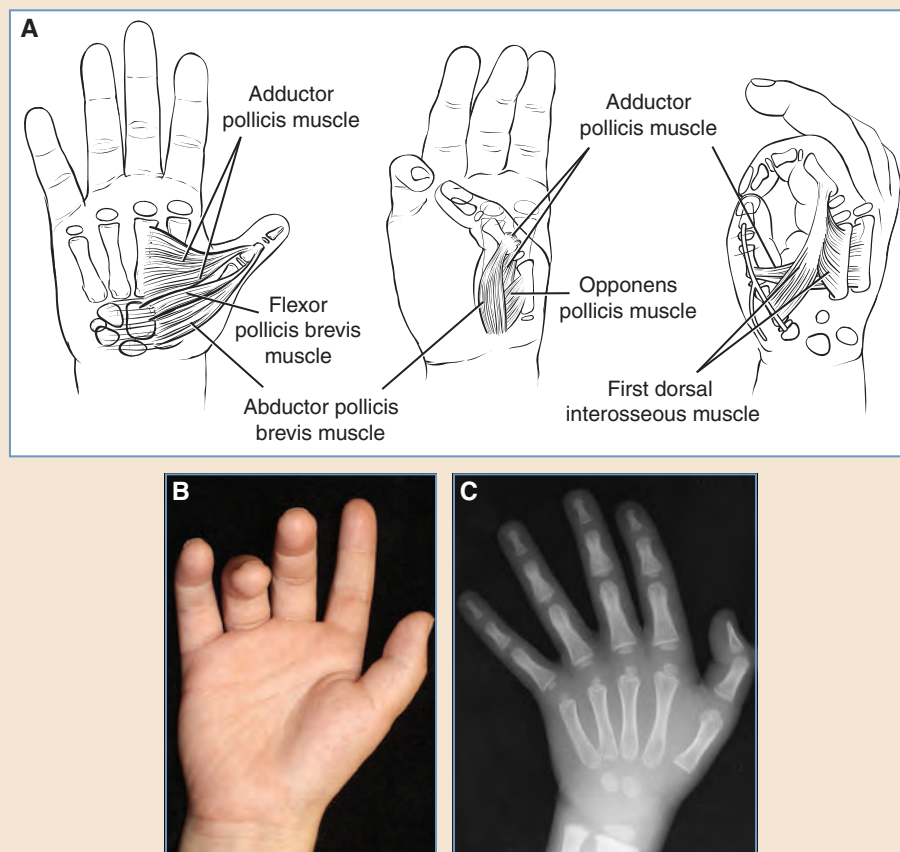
Type I thumb hypoplasia—mild. A, The skeletal ray is well segmented and may be short. All intrinsic muscles and extrinsic tendons are intact. First web space narrowing is minimal to moderate. B and C, Clinical and radiographic appearance of a child who did not require any surgical correction. Although his thenar muscles are weak, there are no significant functional problems.
